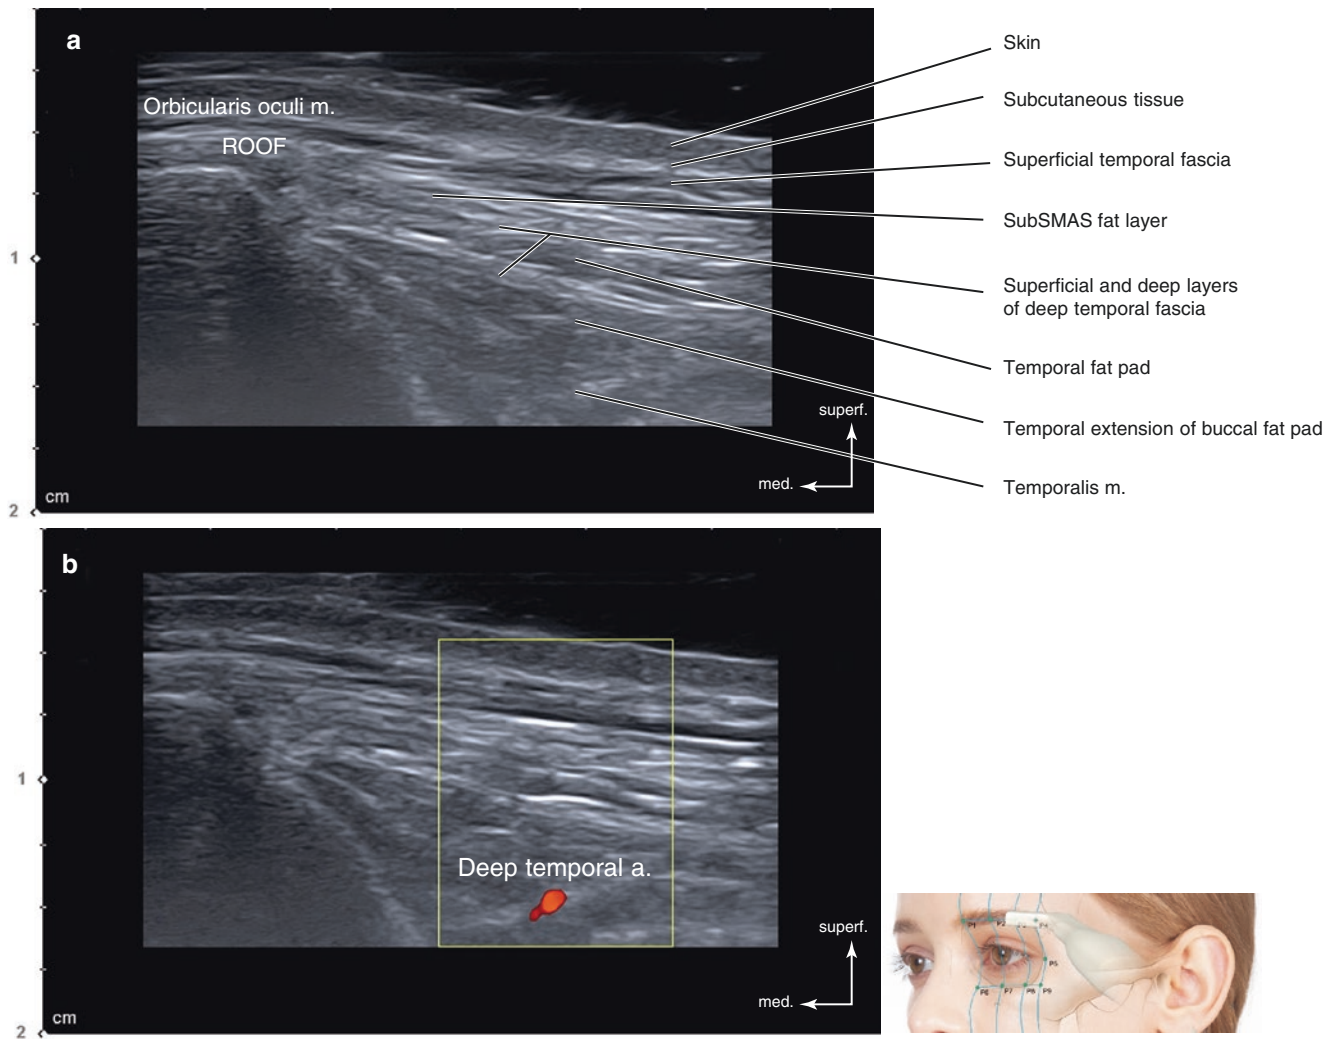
Ultrasonography on the intersection point of TL2 and PL4 (P4). (a) B mode (transverse view, 15 MHz by linear transducer), (b) Doppler mode (transverse view, 15 MHz by linear transducer), (c) B mode (sagittal view, 15 MHz by linear transducer), and (d) Doppler mode (sagittal view, 15 MHz by linear transducer). (Published with kind permission of © Hee-Jin Kim 2020. All Rights Reserved)
